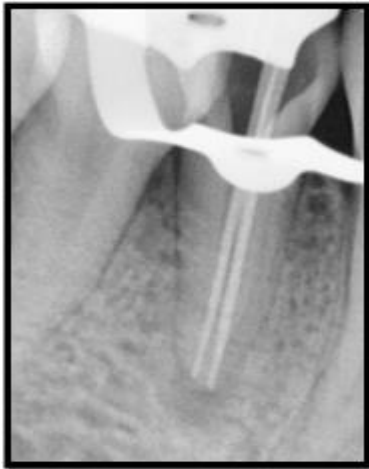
Radiograph showing master cone verification
